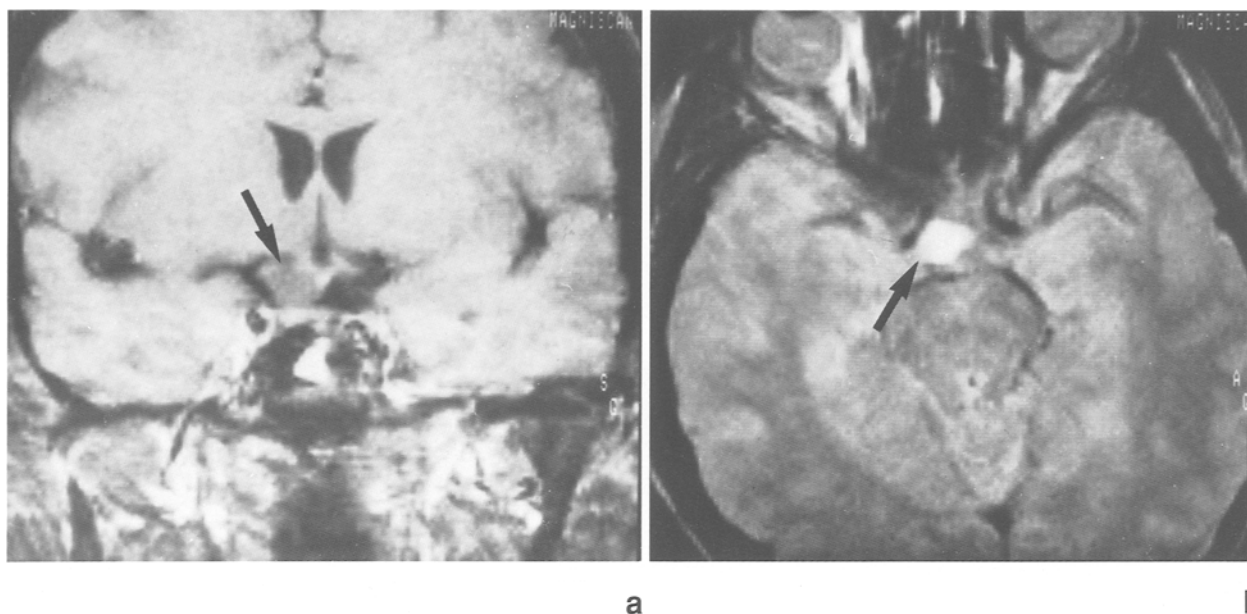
Case 1: (a) Gadolinium enhanced T 1 weighted MRI scan depicts a hypo-intense homogenous lesion (arrow) lying medial to the supraclinoid internal carotid artery. It lies within a space bounded by the pituitary stalk, the right border of the optic chiasma and the right optic tract. This lesion does not show any traces of gadolinium enhancement. (b) T 2 weighted sequences show homogeneous hyperintensity of the lesion
